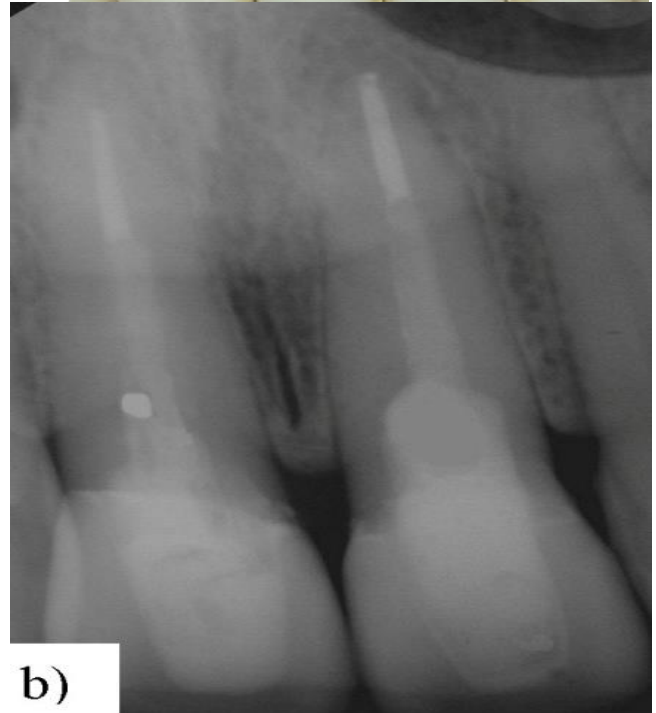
a) Photograph 1 year following perforation repair and after teeth UR1 and UL1 were restored with all ceramic crowns. The sinus tract has completely resolved. d) Periapical radiograph 2 years following perforation repair. Note the MTA in place over the perforation.
